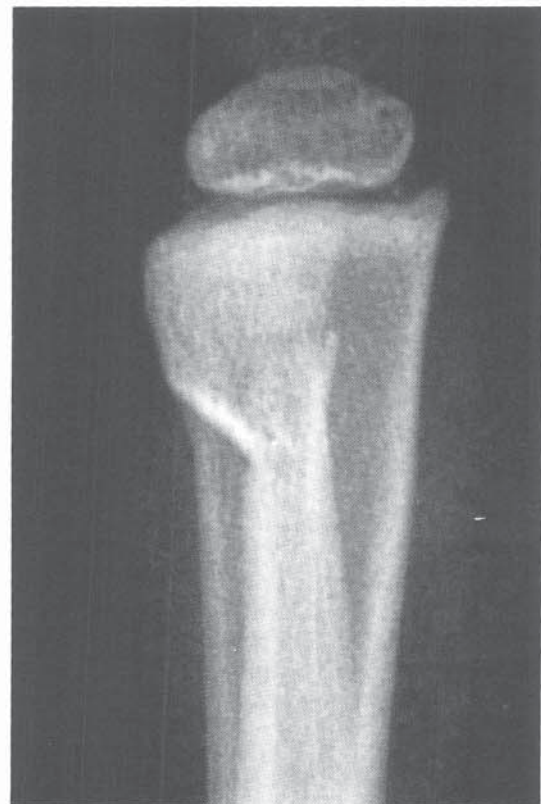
Lateral radiograph of the distal radius showing a buckle fracture of the dorsal cortex. The volar cortex is uninvolved and the dorsal cortex is not completely fractured.
